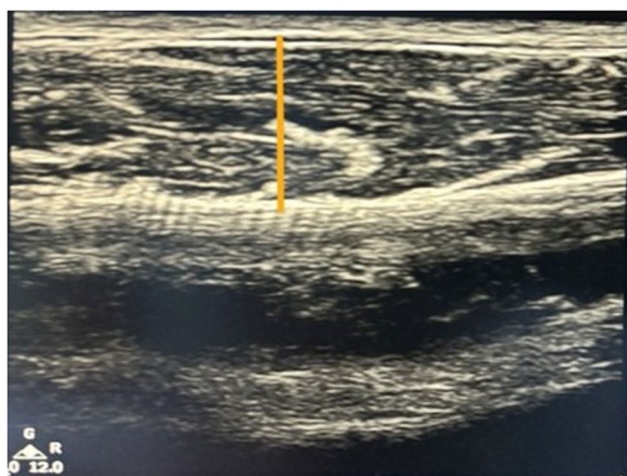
Ultrasonographic image of the massater muscle at resting position
